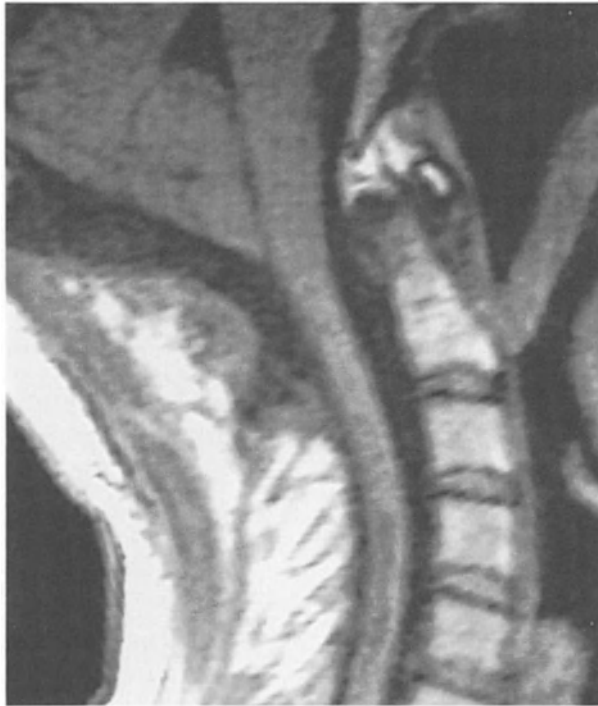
A patient treated with a silastic sheet sutured across the site of dural opening. The pre-operative appearances were similar to those of Fig. 1. Compare this post-operative MRI with Fig. 2. The Silastic has provoked fibrosis and the tonsils are still held in a firm grip with a conical moulding. The patient was worse in almost all respects, the hindbrain headache was incapacitating, arm neurology deteriorated, but the syringomyelia cavity, interestingly, was objectively improved
